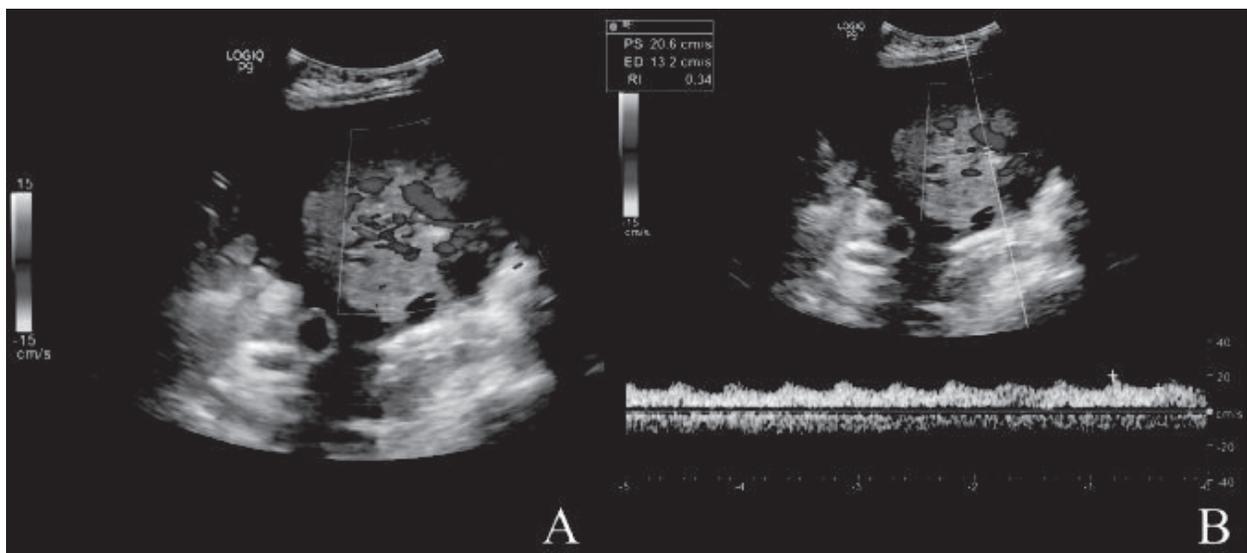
Color Doppler ultrasound. A. Prominent intratumoral vessels. B. Low resistant flow with an RI of 0.34.
